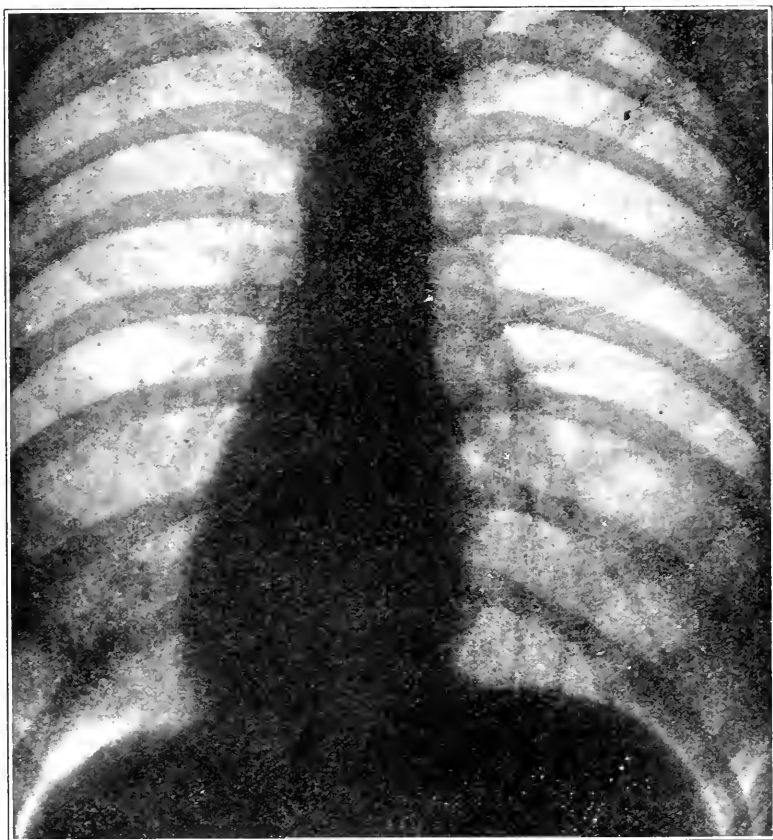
Radiograph—the chest of the asthenic habitus.
